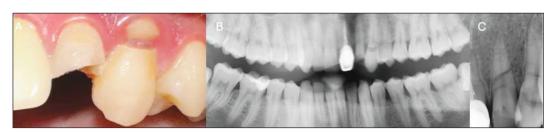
A) Intraoral view before treatment; B) Panoramic radiograph before treatment; C) Periapical radiograph before treatment.
